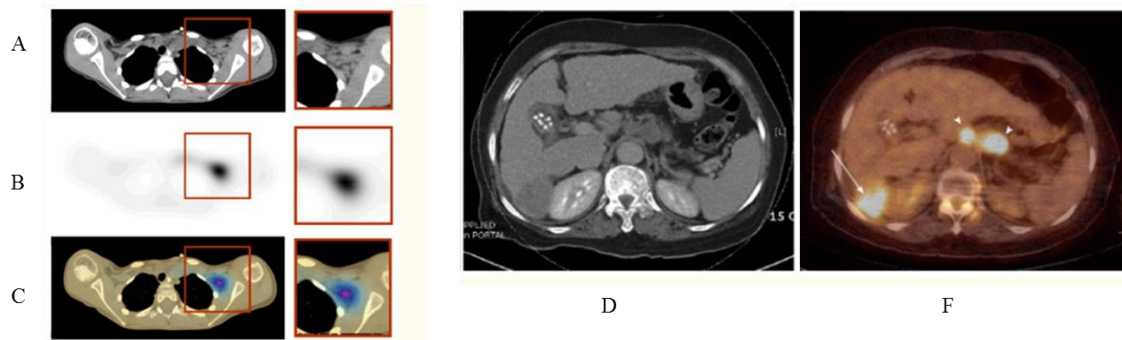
Example of fused image available from combined CT–scintillation camera imaging system. CT image (A) is shown along with spatially correlated SPECT image (B) indicating  $^{131}\text{I}$ -MIBG uptake in lymph node in patient's left axilla and fused SPECT/CT image (C) [73],  $^{18}\text{F}$ -fluorodeoxyglucose PET/ CT in hepatocellular carcinoma; CT image (D) and fused image PET/CT (F) show hot uptake in the primary lesion (arrow) in the right lobe of the liver and regional lymph node metastases (arrowhead), reproduced with permission [74].
